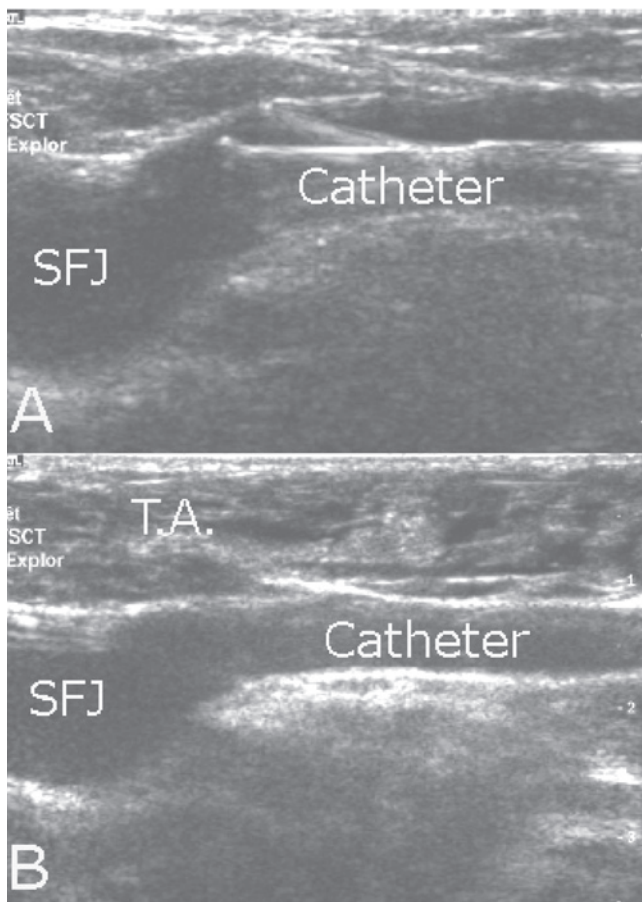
Administration of the tumescent anesthesia into the Saphenous Compartment is monitored by ultrasound. SFJ: Saphenofemoral Junction; T.A.: Tumescent Anesthesia. (Adapted from Pichot O, Atlas of Ultrasound Images, Copyright VNUS® Closure.)
